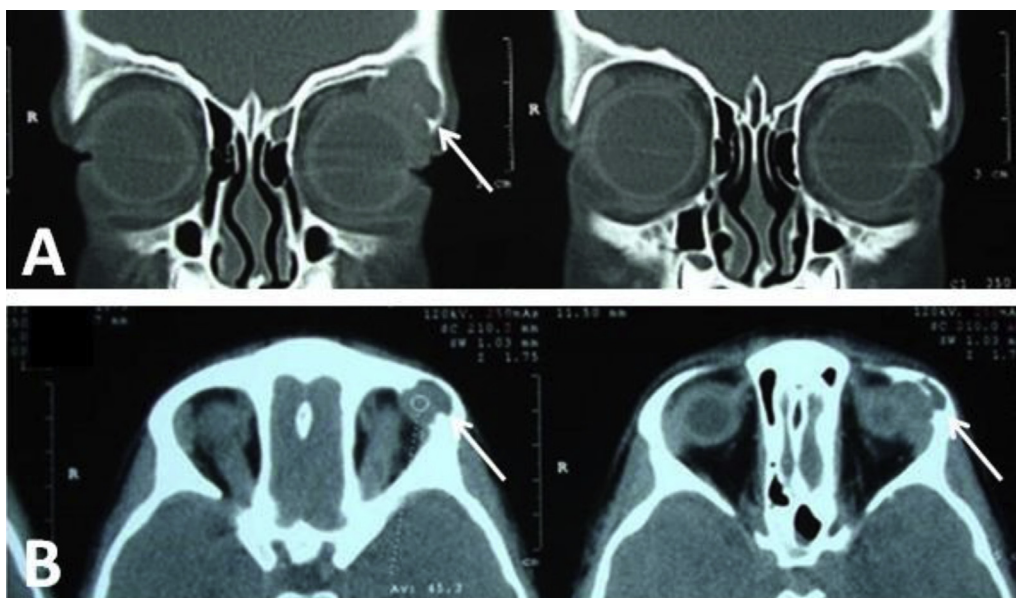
Orbital Computed tomography: A. Coronal view demonstrated an isodense homogeneous well circumscribed mass with irregular borders in the lateral and superior parts of the left orbit with extension to lacrimal gland site with extensive supralateral frontal bone erosion (Arrow). B. Axial view of the findings described (Arrow).
